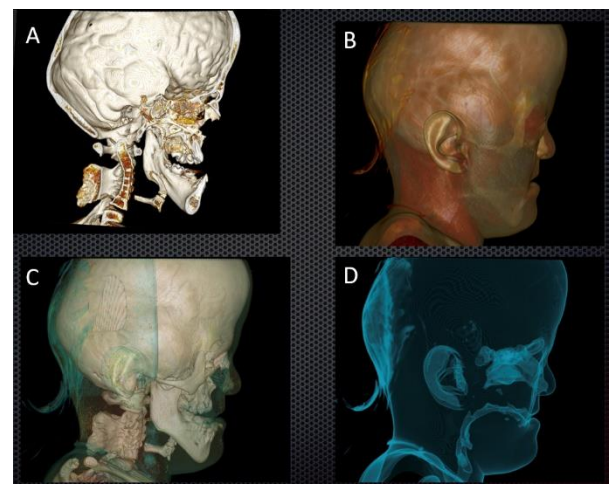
Faciocraniosynostosis typical findings. A) Lateral view of 3D CT scan showing signs of intracranial pressure in the inner part of skull; B) exorbitism; C) maxilar retrusion, D) obstructive sleep apnea; E) Fusion of images.
